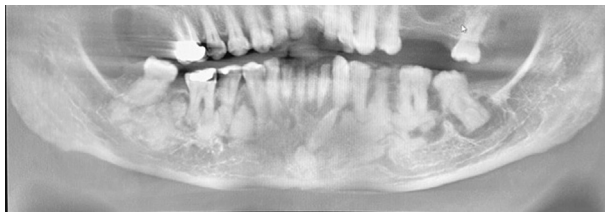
Panoramic radiograph showing multiple mixed radiolucent-radiopaque lesions of the mandible.
